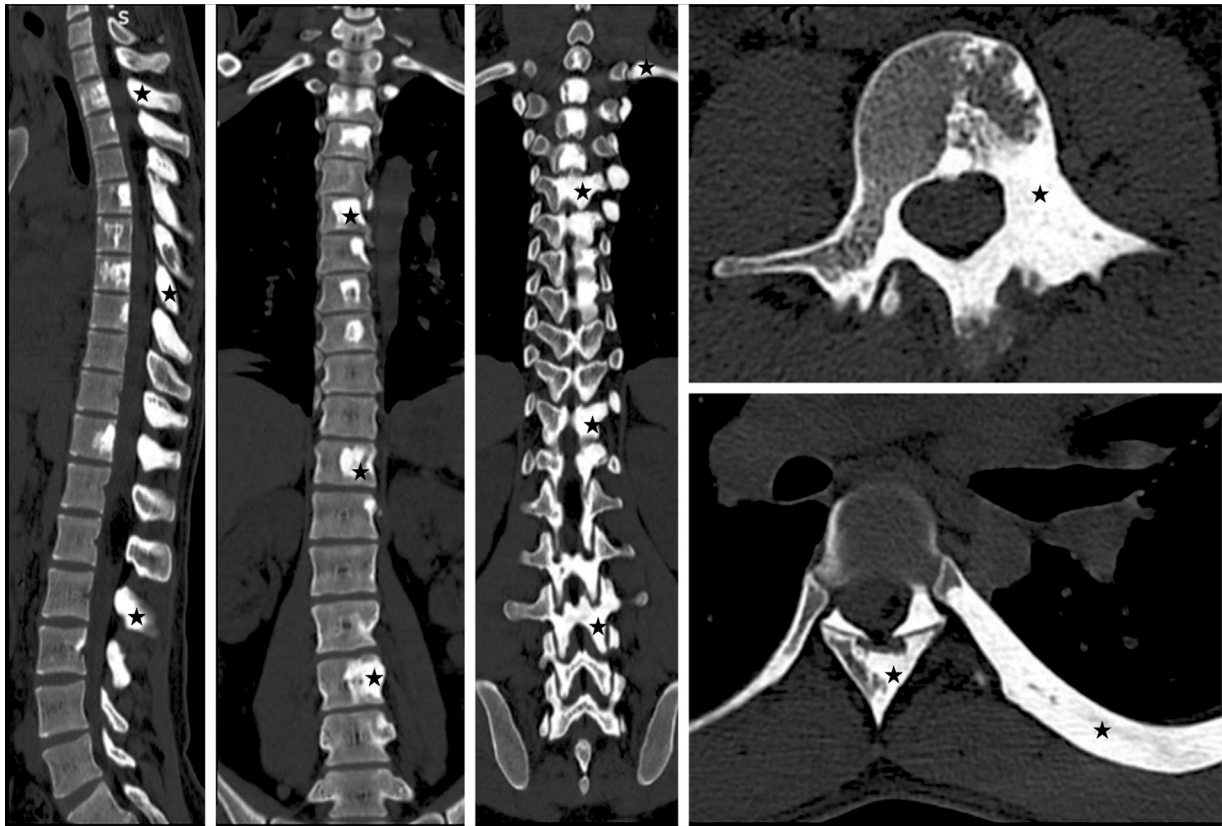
Computed tomography sagittal and axial images showing diffuse hyperostosis (asterisk) involving left half of multiple vertebral bodies, pedicles, left ribs.
